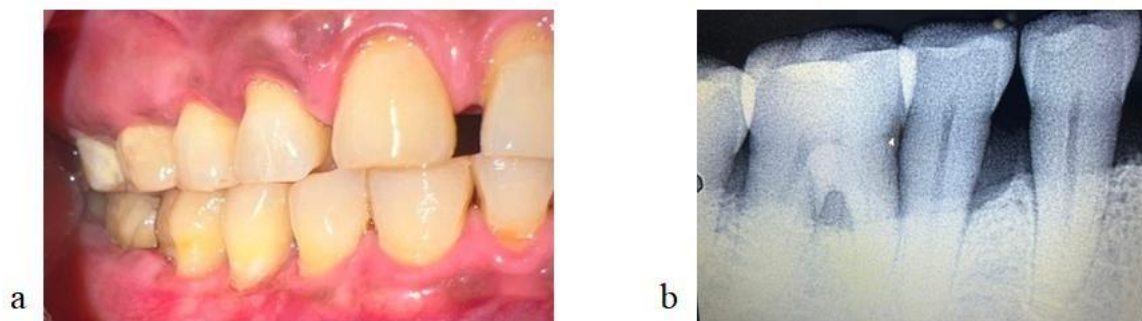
3 months after surgery a. clinical view b. Radiographic view
